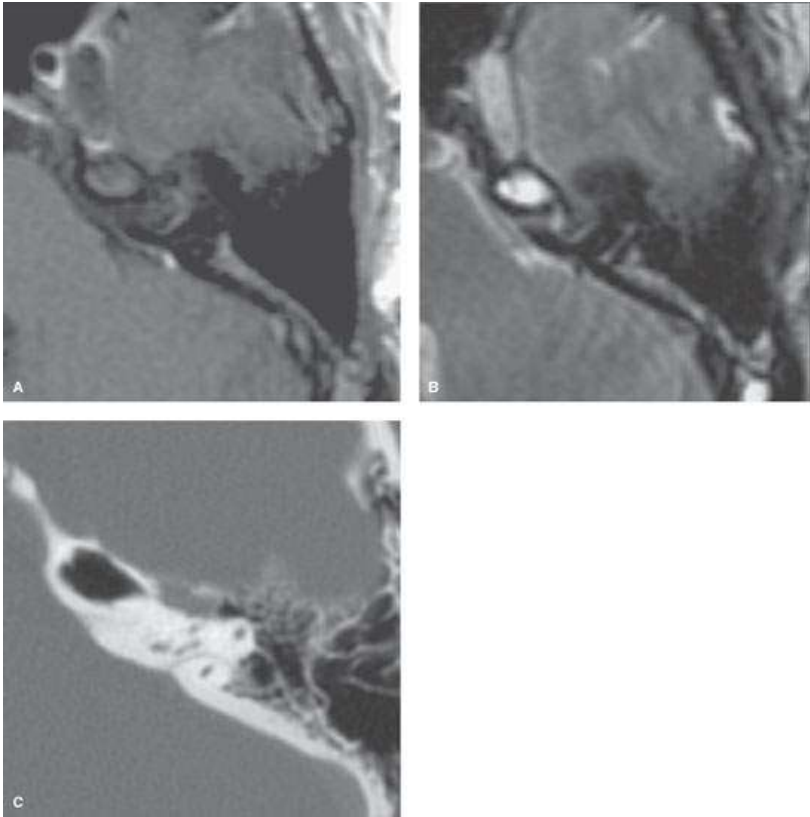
Variations of the petrous apex. A, B: T1- and T2-weighted images showing abnormal signal intensity in the left petrous apex, consistent with fluid. C: Computed tomography image taken a few weeks earlier showing a well-pneumatized petrous apex, confirming fluid and ruling out a mass lesion.
